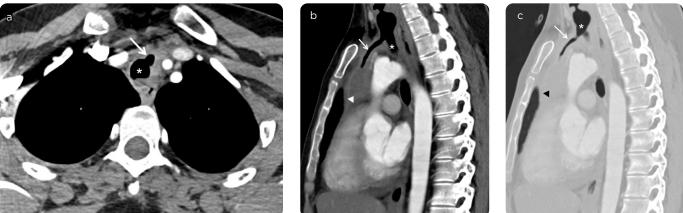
Chest CT with contrast medium, a) axial view in soft tissue window, b) sagittal view in soft tissue window and c) sagittal view in lung window. There is evidence of abnormal communication or fistula (white arrow) between the trachea (asterisk) and the mediastinal mass (arrowhead).
